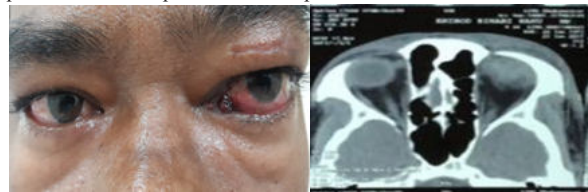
Firm mass in left orbit; Clinical presentation and Axial CT Scan
